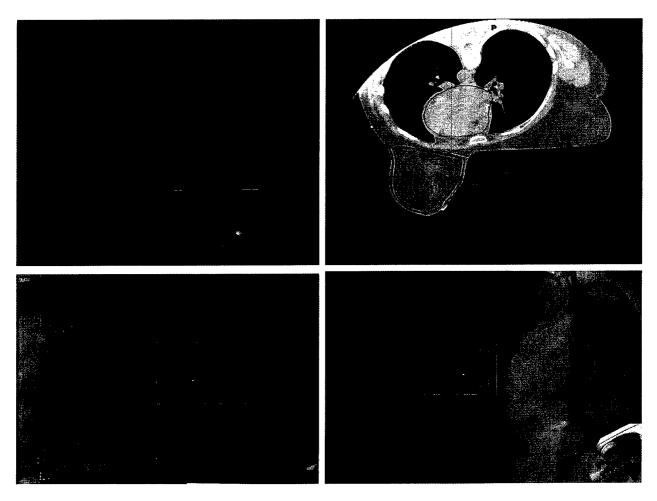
(Upper) Example of relationship of tumor bed to planning target volume (PTV) demonstrated; tumor bed in red wash, PTV in blue, heart in pink, and lung in light green. PTV represents a 1.5-cm margin on tumor bed. (Lower) Digital reconstructed radiographs, right anterior oblique and left posterior oblique portals for left-sided breast cancer.
